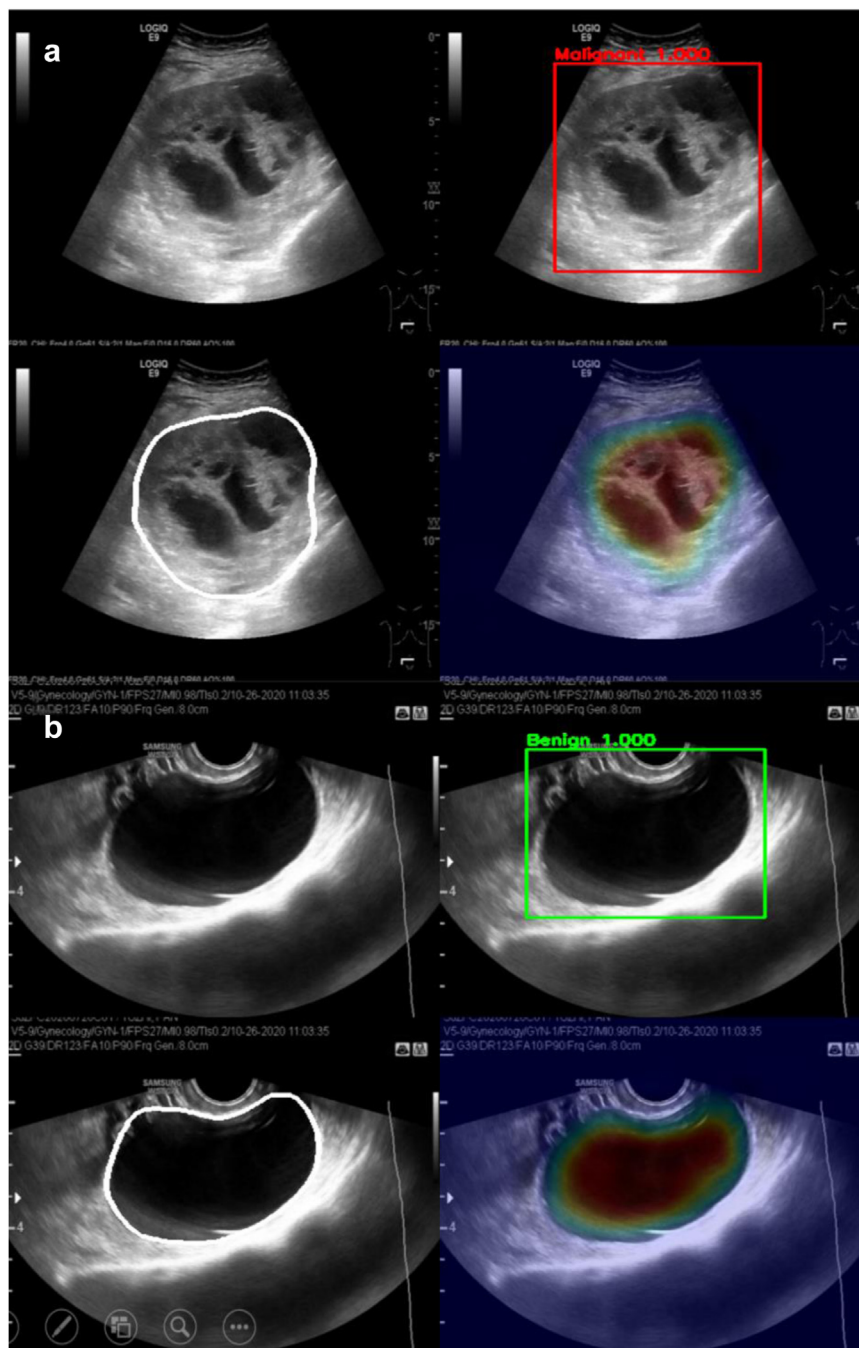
Two types of ovarian masses detected, segmented, diagnosed, and interpreted by AI system. (a). Keyframe of greyscale ultrasound videos in a 64-year-old woman with solid component(s) within a multilocular cyst. The AI system can detect and map the edges of the mass, and make malignant classification and probability in real time. The final diagnosis result provided by AI system was consistent with the pathological result after surgery (endometrioid carcinoma). The AI system gives interpretable heat maps in real time, allowing doctors to pay more attention to the irregular compartments and solid components. (b). Keyframe of greyscale ultrasound videos in a 52-year-old woman with a unilocular anechoic cyst. The AI system can detect and map the edges of the mass, and make benign classification and probability in real time. The final diagnosis result provided by AI system was consistent with the pathological result after surgery (serous cystadenofibroma). The AI system gives interpretable heat maps in real time, allowing doctors to pay more attention to the anechoic cystic part. AI, artificial intelligence.
